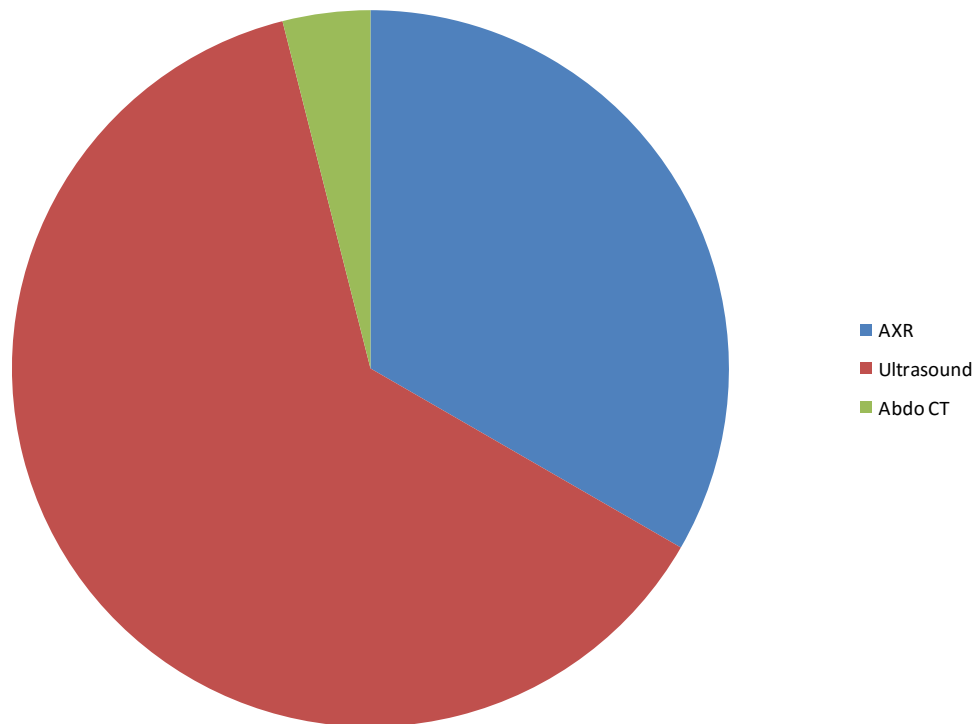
Overall, 19% of presentations had imaging – ultrasound being the imaging modality of choice followed by AXR. 135 Ultrasounds were ordered for abdominal pain, 35 abdominal X-rays and 8 CT scans. Of note compared to abroad, the rate of CT imaging was just under 1%.
